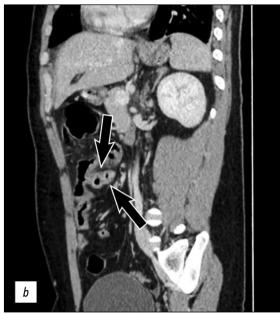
Axial (a) and sagittal (b) post-contrast computed tomography images showing an intense contrast enhancement of the intestinal wall at the level of the same blind-ended loop (arrows) and some adjacent gaseous nuclei with antideclive arrangement, diagnostic for perforation.
